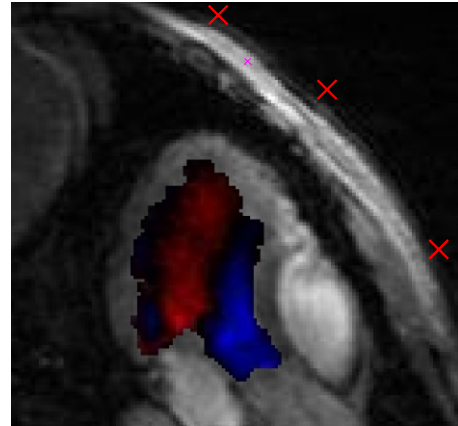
Virtual color Doppler image generated from PC-MRA datasets. \times : Virtual probe location
